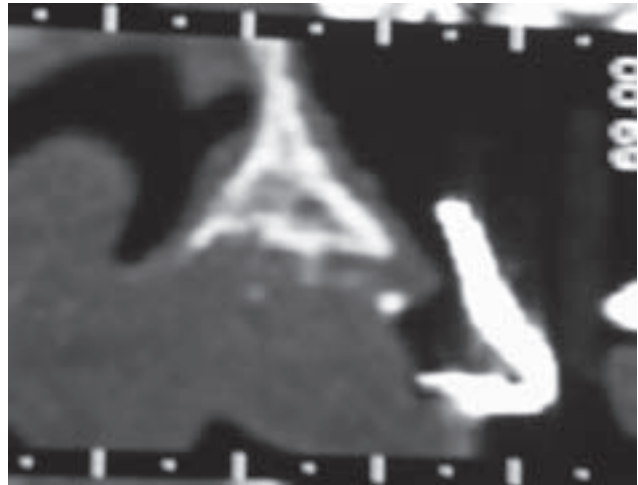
Radiographic cross-sectional view of severely angled ridge.
